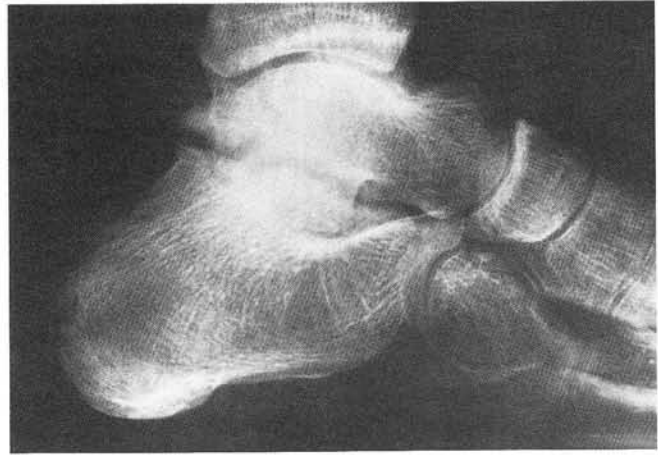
Sixteen months postoperative lateral radiograph. Note the severe degenerative joint disease of the subtalar and ankle joints.
